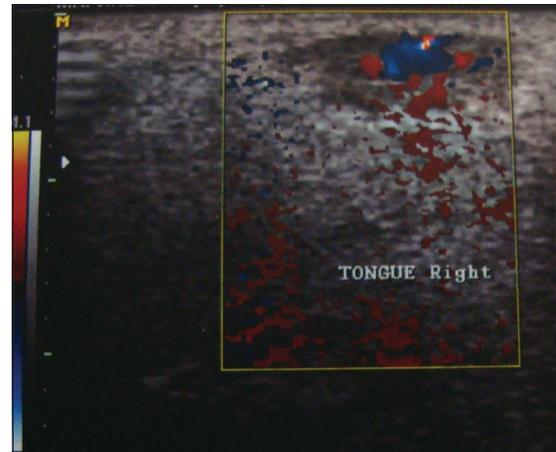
Ultrasonography of tongue lesions with compressible cystic septate masses and low velocity color flow detected on both color Doppler and power Doppler
